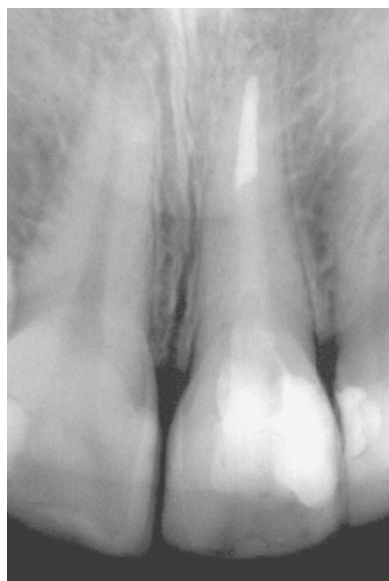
Radiographic image used to confirm the presence and condition of the endodontic treatment and fiberglass post.
